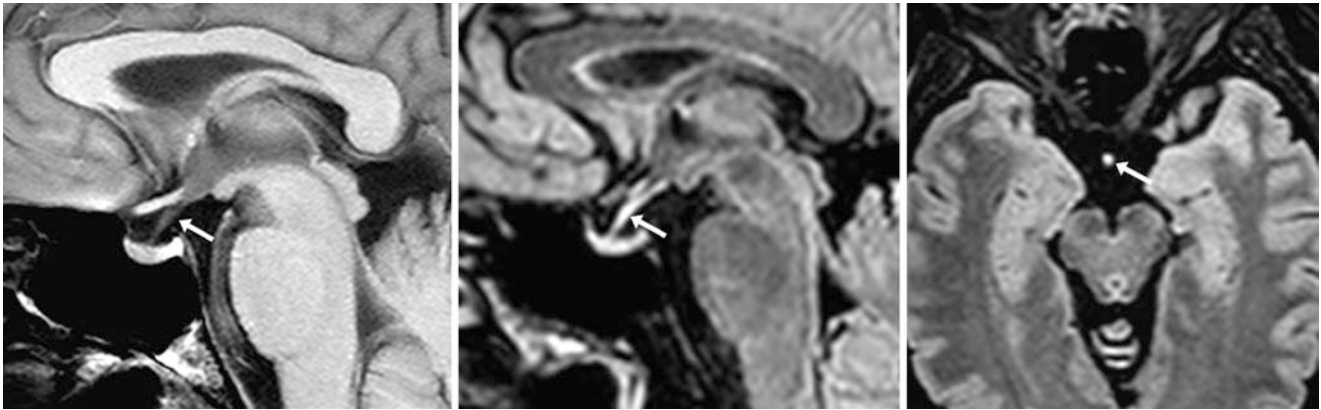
Normal infundibular hyperintensity on noncontrast 3D FLAIR. In a 58-year-old female postconcussion (negative 1.5 T MRI) the infundibulum (*arrows*) appears normal on a sagittal T1WI (*left*) but
